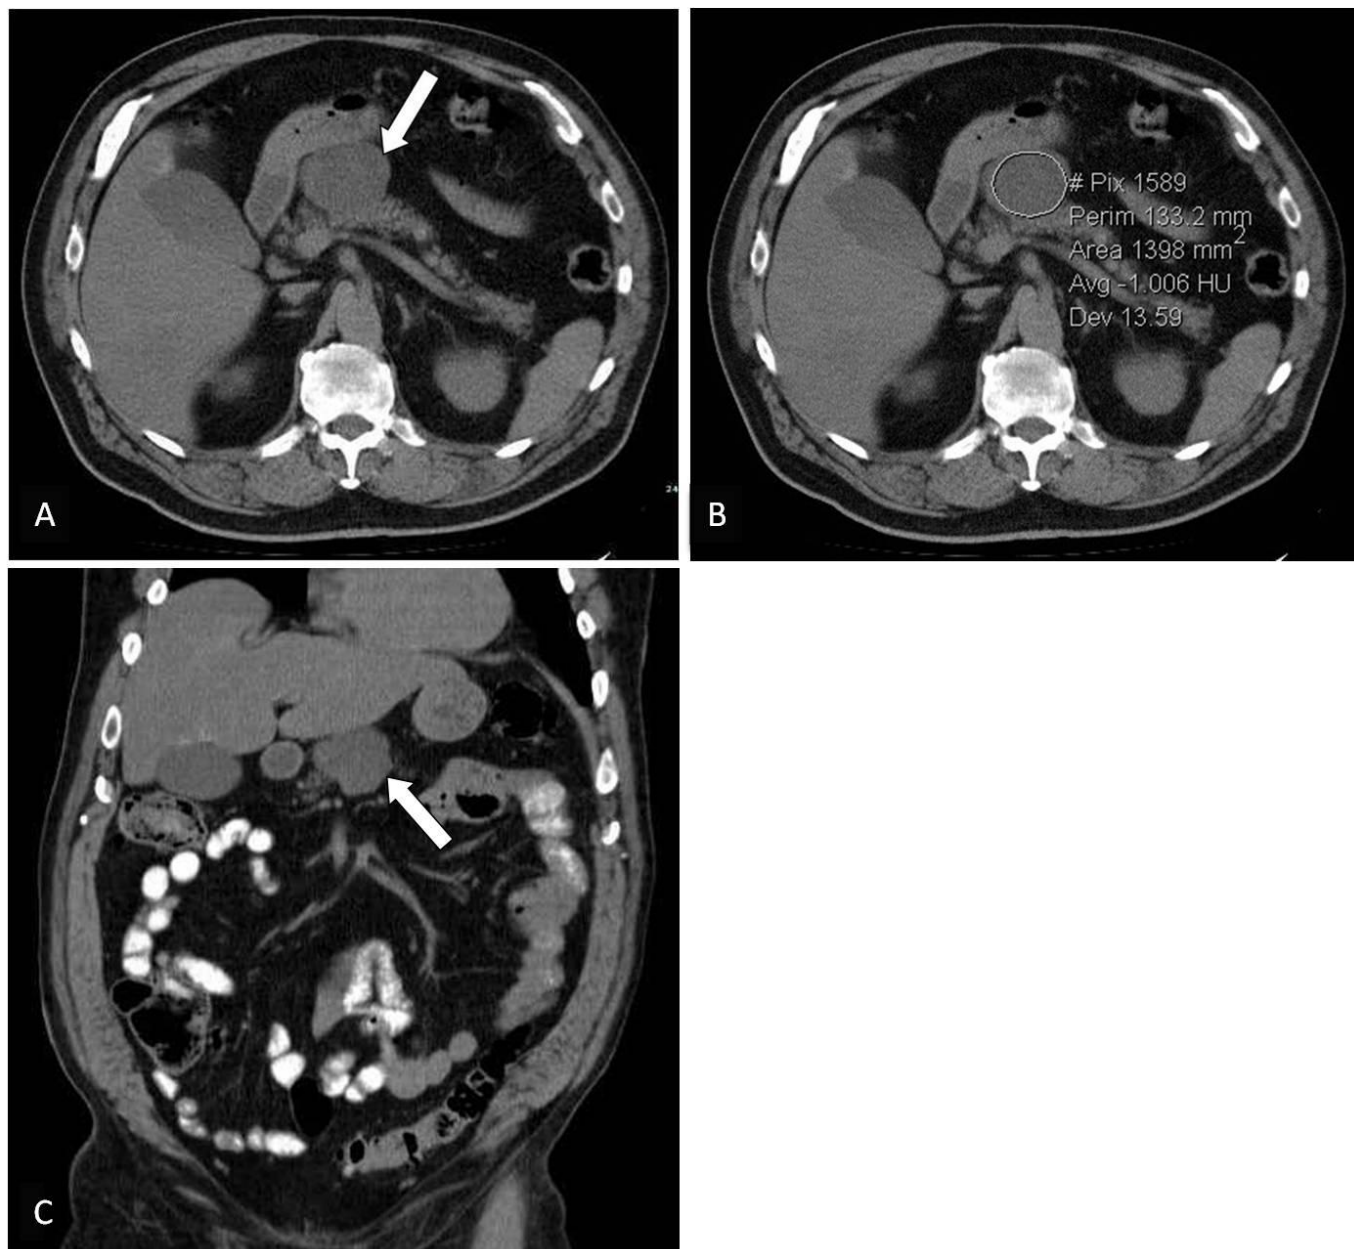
63 year old male with a dermoid cyst of the pancreas. Axial and coronal, non-contrast enhanced abdominal CT images performed using a Toshiba Aquilion 16 CT scanner (kVp 120, mAs setting 200 (range 10 - 500), 1 mm slice thickness). Images demonstrate a 5.7 x 5.1 x 4.1 cm cystic-appearing mass (Fig 1A, 1C, arrows) that projects cephalad and anteriorly from the body of the pancreas. The Hounsfield unit measurement of the mass was -1 (Fig 1B), which suggested a cystic lesion. No adjacent inflammation, ductal dilatation, or adenopathy was seen and the bowel was unremarkable.
